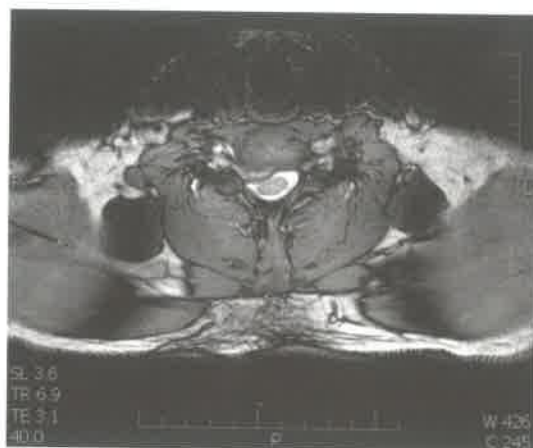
Preoperative MRI: a prolapse in the right side of the disk C6/7 with the osteopyhte horizontal cut.
